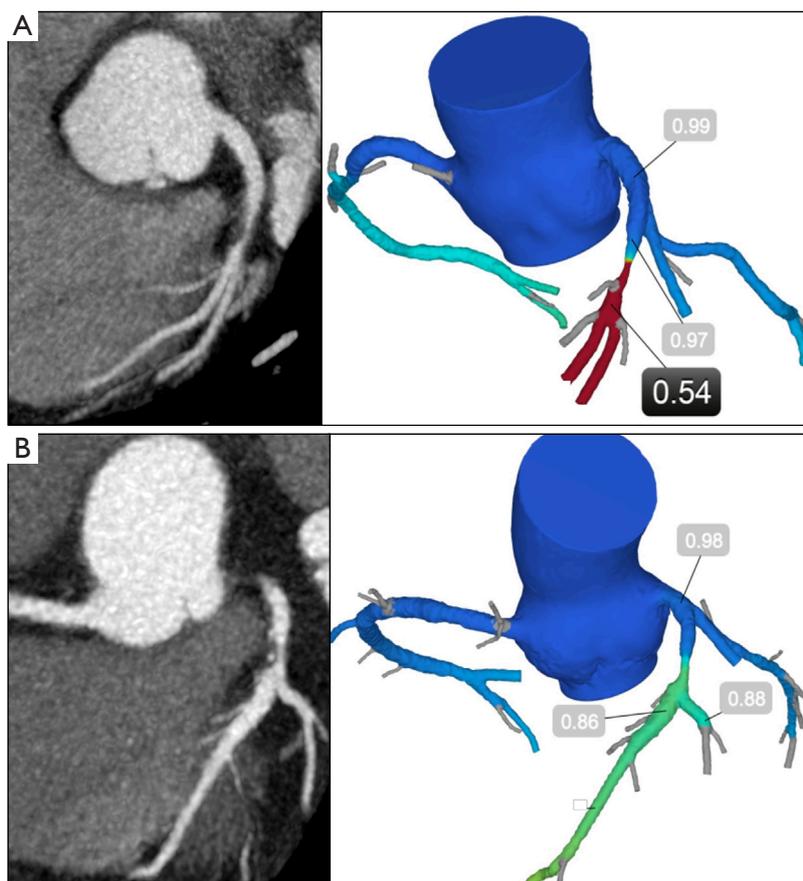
Intermediate lesions with (A) positive flow reserve computed tomography (FFRCT) and (B) negative FFRCT.
